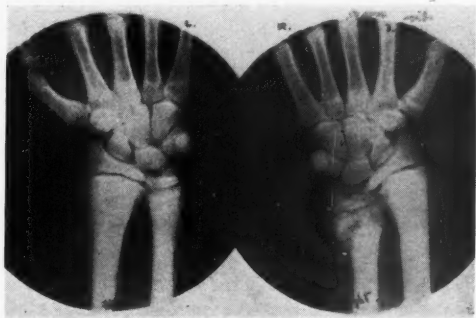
The special type of radiographic appearances in renal rickets. The changes are asymmetrical (much more marked at the right wrist). They involve the whole metaphysis and not only the epiphyseal line.
